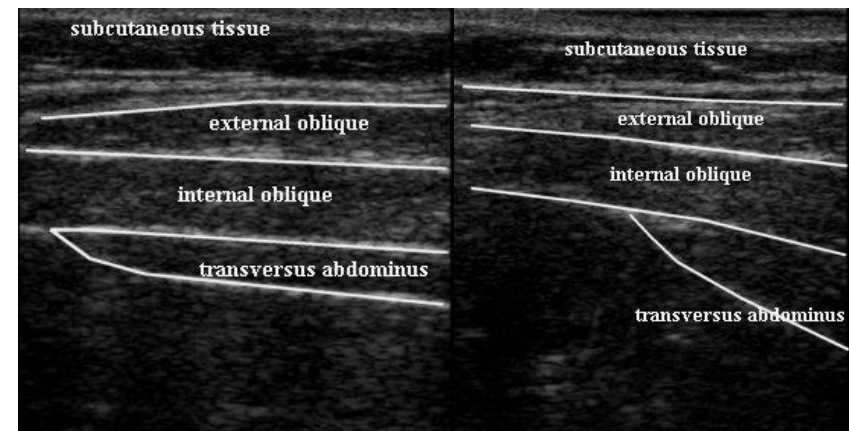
ultrasound images of transversus abdominus first in a relaxed then contracted state
